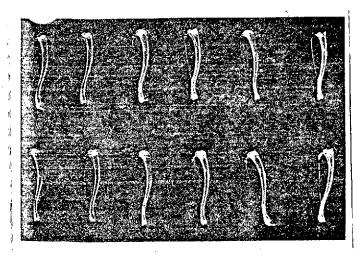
Radiography of tibiae and peroni. From left to right and from top to bottom:
